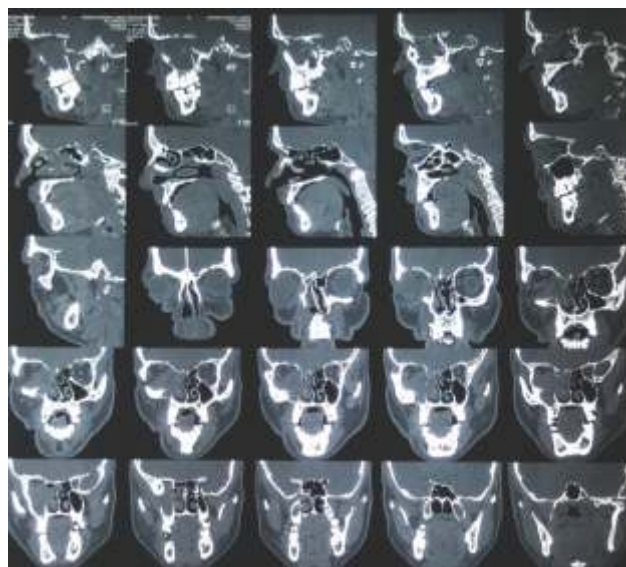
Pre Operative CT Scan Showing Haziness in the Right Maxillary Sinus
